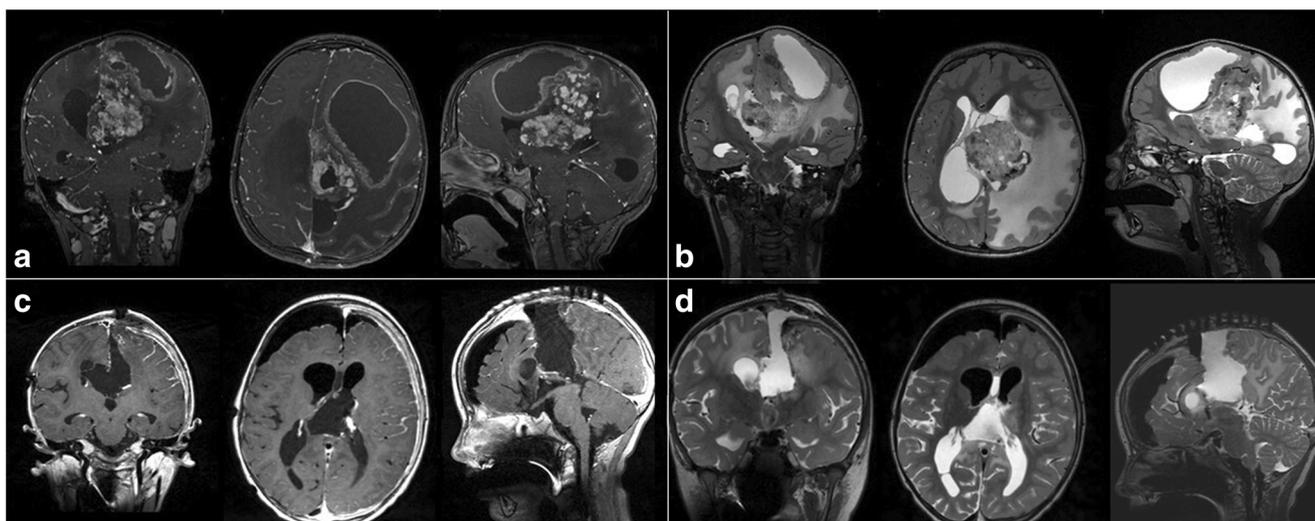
a Preoperative MRI of the 4-year-old female patient with a cystic-solid intraventricular ependymoma shows an irregular, contrast enhancement in T1-weighted images with gadolinium. b T2-weighted images showed the diffuse peritumoral edema around the lesion which extends
